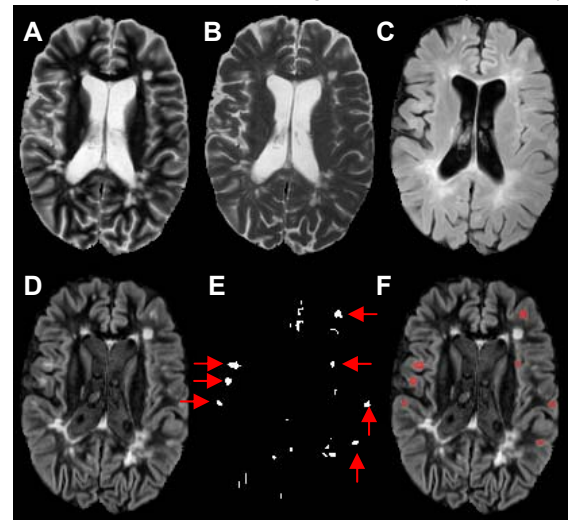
A: PSIR magnitude reconstructed; B: T2; C: FLAIR; D: DIR; E: regional maxima obtained with the application of morphological grayscale reconstruction; (F) operator selected cortical lesions superimposed on DIR images.
